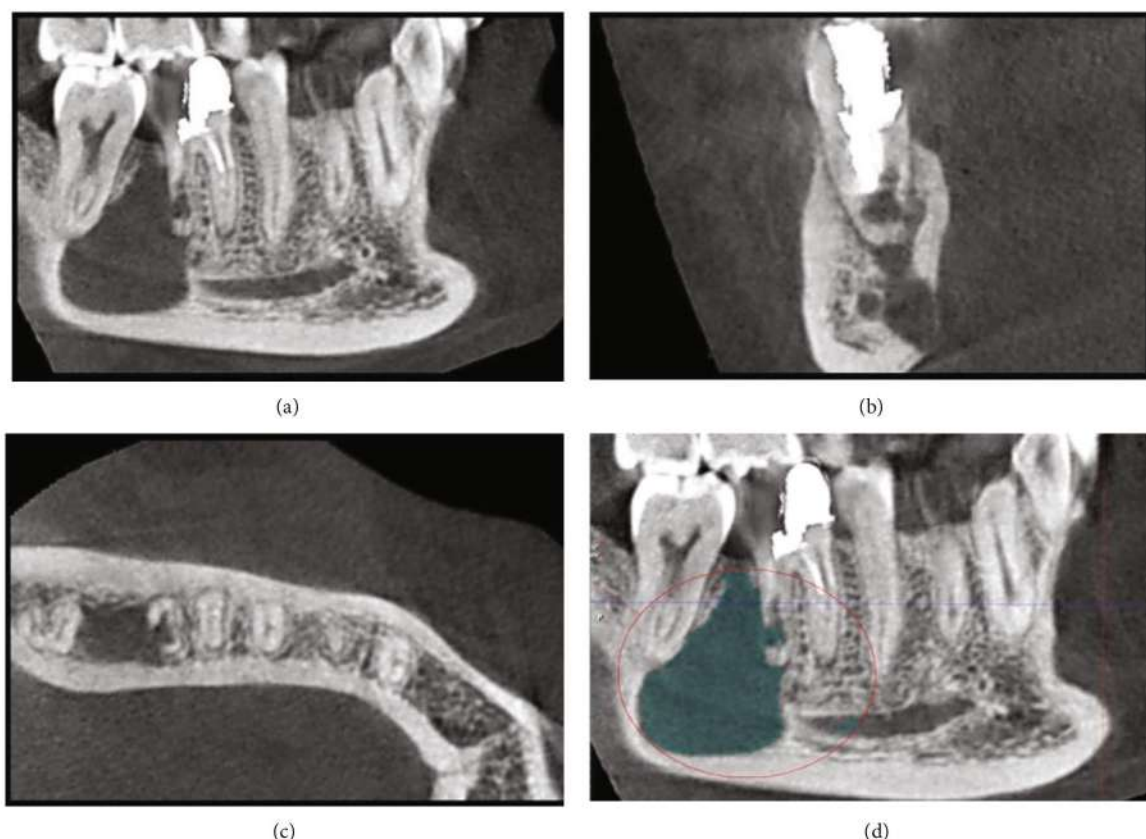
(a) CBCT revealing a well-defined unilocular lesion between the second and first right mandibular molars. (b) Sagittal view showing the expansion of the lesion toward the lingual wall and the consequent thinning of the lingual plate. (c) Axial section showing a perforation in the distal and lingual aspects of the apical third of the distal root of the right first molar. (d) The main osteolytic lesion appears in continuity with the perforation in the distal root of the right mandibular first molar.
